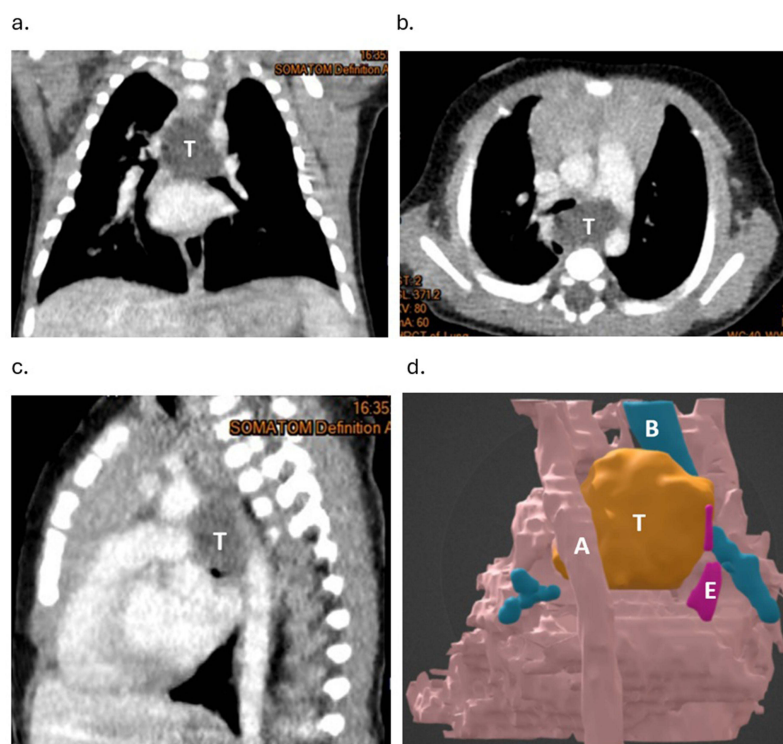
Computed tomography (a–c) revealed a well-circumscribed mass measuring approximately 2.4×1.5 cm located in the middle mediastinum at the T4–T7 level. The three-dimensional reconstruction (posterior view, (d)) demonstrates the tumor (T) in close proximity to critical structures, including the carina, bilateral bronchial trees (B), esophagus (E), and thoracic aorta (A).
